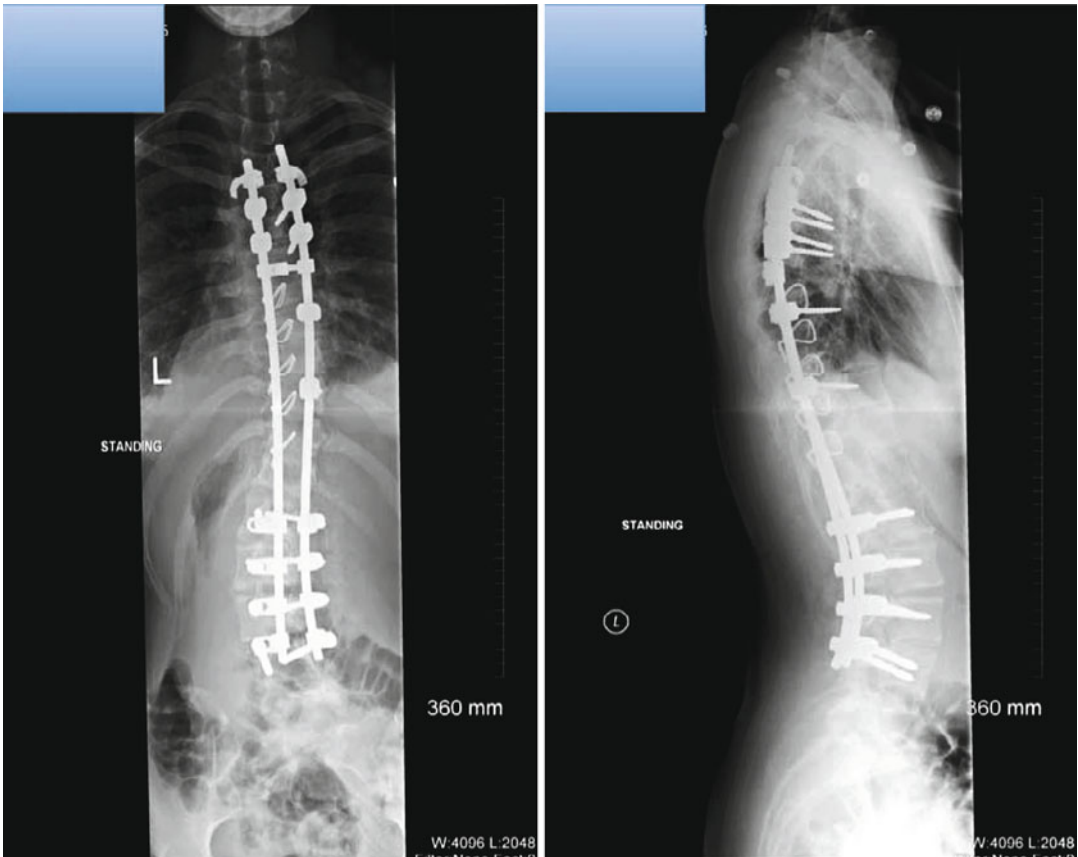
Postoperative radiographs showing correction of deformity and posterior instrumentation
